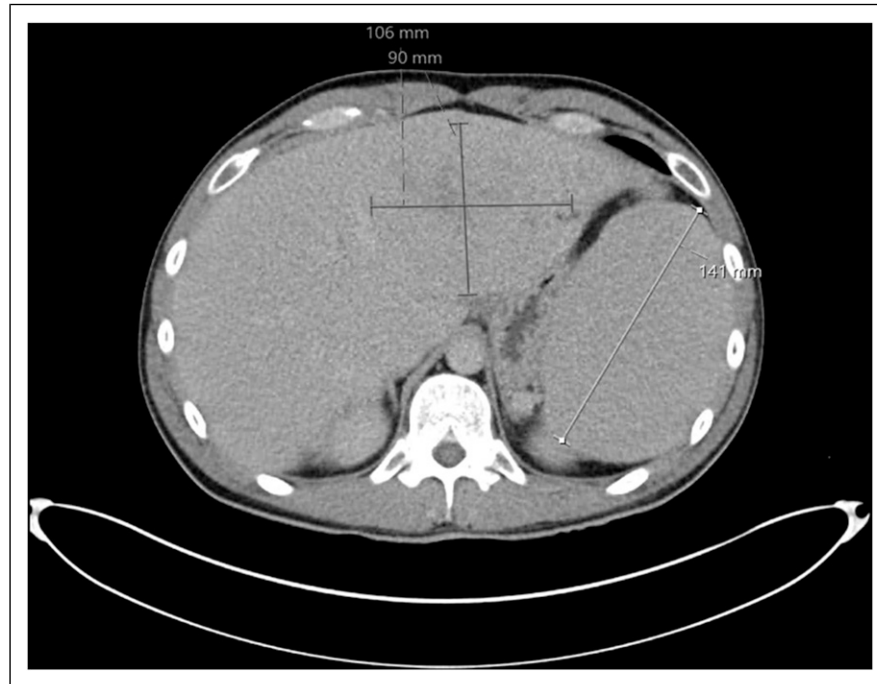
Contrast-enhanced computed tomography (CT) scan demonstrating the extent of disease involvement in the liver and upper abdomen prior to initiation of treatment with aldoxorubicin, October 2015.
